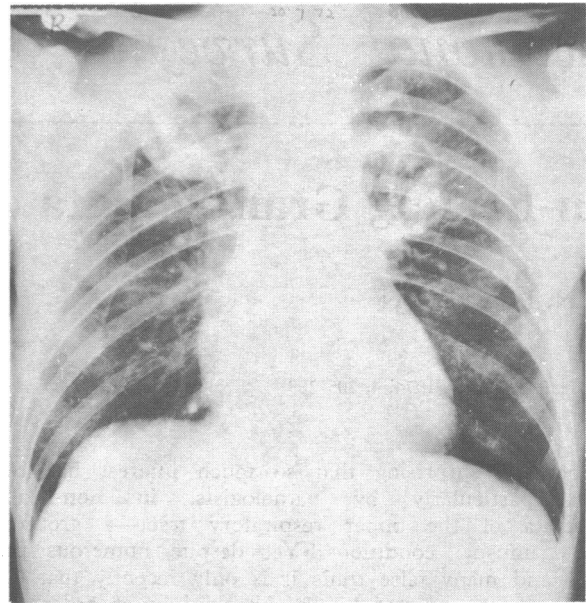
Case 24. Chest x-ray picture of patient with Wegener's granulomatosis showing bilateral apical abscesses.
